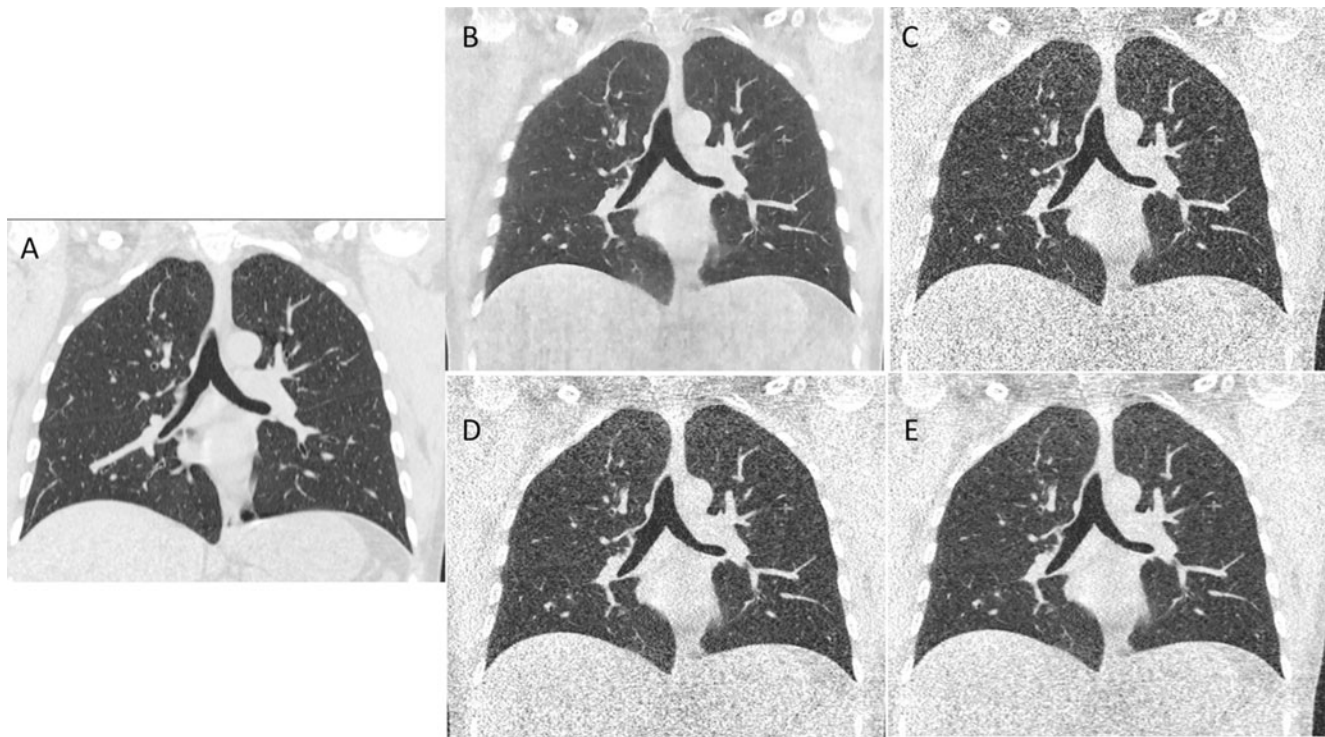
Image quality. Coronal reformatted CT demonstrating the image quality of a diagnostic CT (a). The same patient is presented after an ultra-low-dose acquisition, reconstructed with a MBIR (b), FBP (c), ASIR-40 (d) and ASIR-80 (e) algorithms. There was a clear reduction
